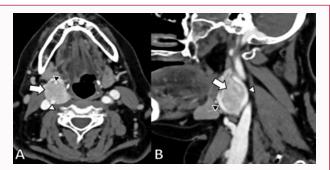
a) Axial reformatted CT angiography images showing a welldelineated intensely homogenously enhancing mass (arrow) at the bifurcation of the common carotid artery. The mass is closely related to the internal (white arrowhead) and external (black arrowhead) carotid arteries. b) parasagittal reformatted image demonstrates splaying of the ICA and ECA, the so-called lyre-sign.
